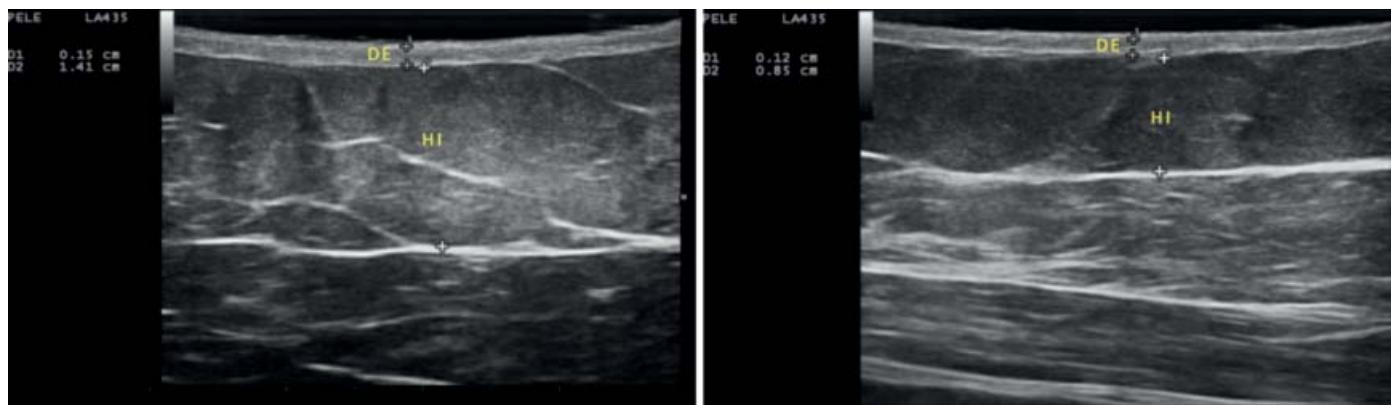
Evaluation of an ultrasound image obtained before (DoA) and after (D31B) the application of low-frequency laser (DE - dermis, HI - hypodermis).
